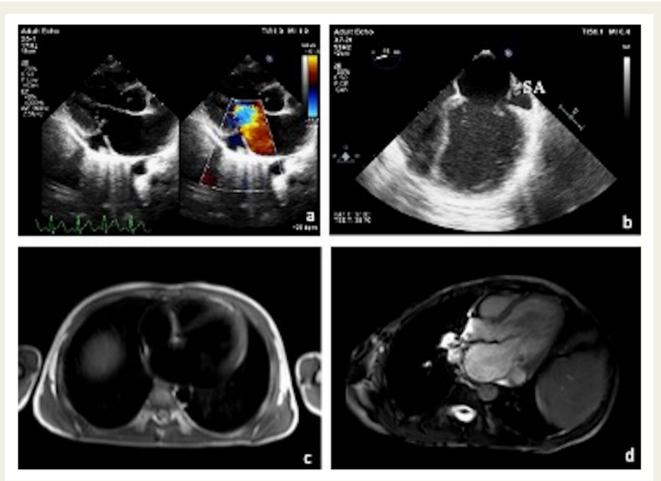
(A) Echocardiogram showing submitral aneurysm (SA) under the posterior mitral leaflet communicating with the left ventricle with vegetation inside the aneurysm. Colour Doppler showing blood in and out of the aneurysm. (B) Transoesophageal echocardiogram (TOE) showing vegetation over the posterior mitral leaflet and also in the aneurysm. (C) Cardiac magnetic resonance black blood image [frame from half-Fourier single-shot turbo spin-echo (HASTE) axial sequence]. (D) Bright blood image (frame from SSFP sequence) showing small submitral aneurysm.
